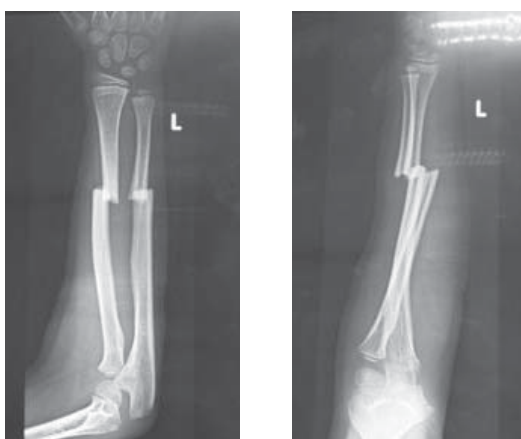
Pre-operative x-rays radius/ulna of skeletally immature boy
